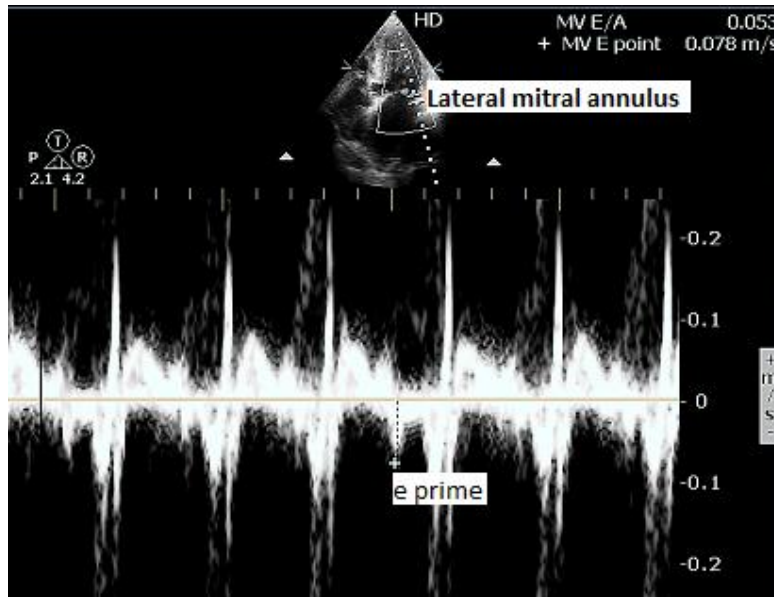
Tissue Doppler at lateral mitral annulus
